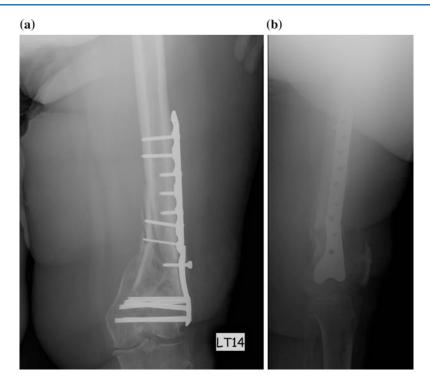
a Anteroposterior and b lateral radiographs of the left knee 2 years after the initial fixation showing loosening of hardware and nonunion. a The loose screw is
